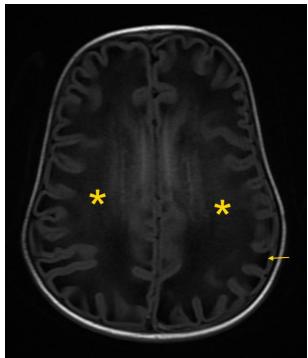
Axial T1 MRI showing bilateral symmetrical diffuse white matter hypointensity (\*) with involvement of subcortical U fibres ( arrow).
